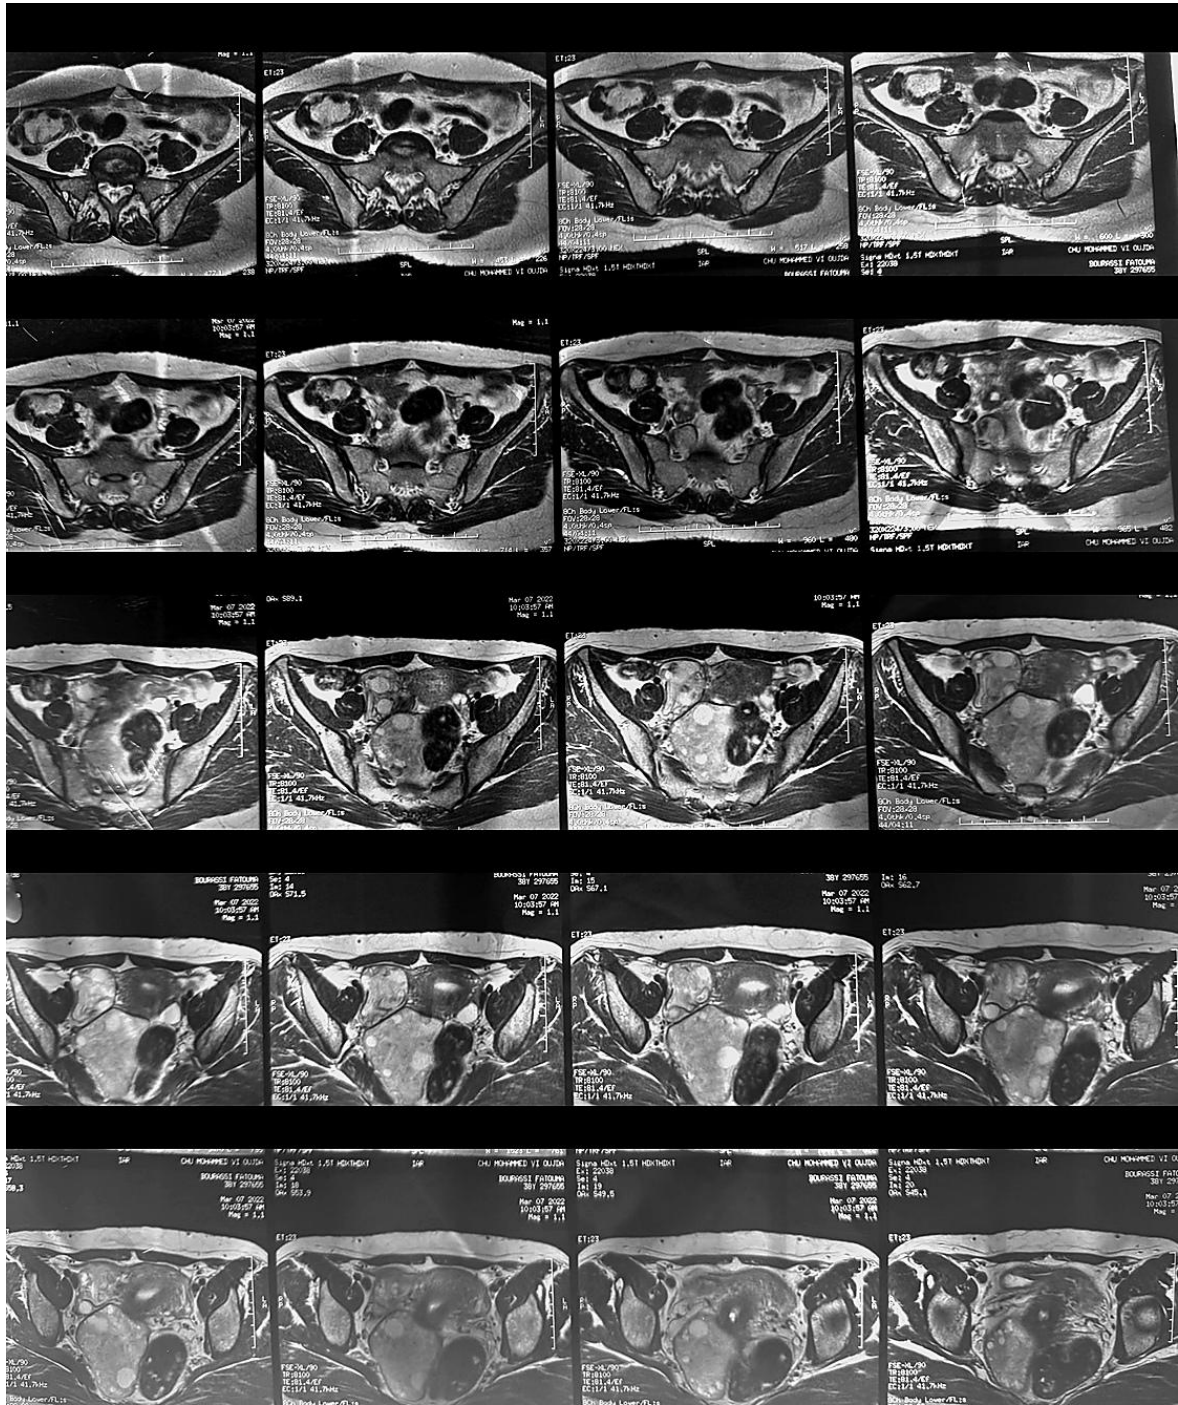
Pelvic MRI dated 7 March 2022, axial image sheet, cropped and anonymized.
